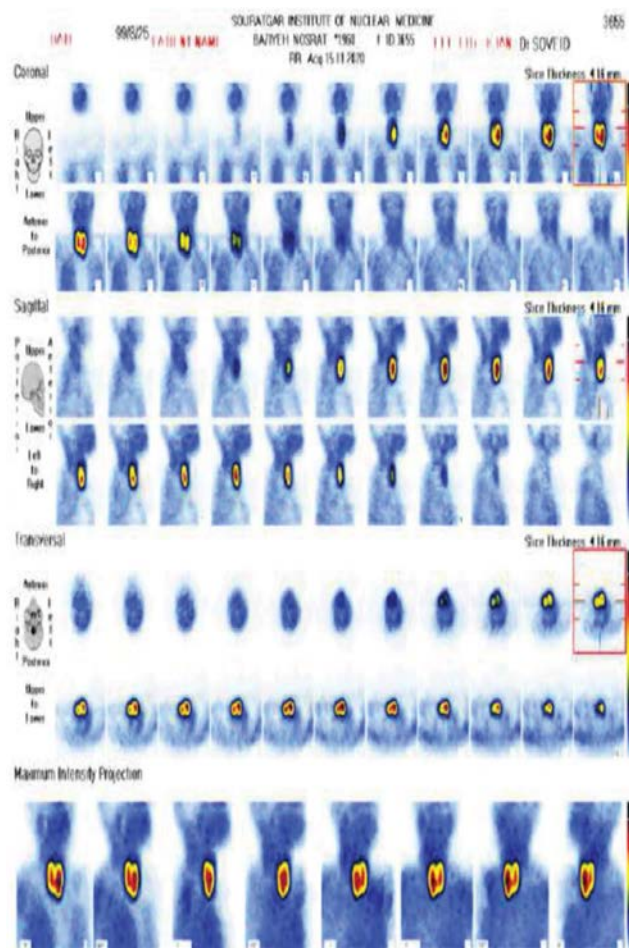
53-year-old woman was consulted for hyperparathyroidism due to severe fatigue and mild dyspnea. Individuals are more often diagnosed today through routine biochemical laboratory testing done for other purposes [1]. Laboratory assays showed hypercalcemia: 10 mg/dL, high serum level of parathyroid hormone: (80 pmol/L), and normal serum phosphorus level 3 mg/dL. [<sup>99m</sup>Tc]MIBI parathyroid scintigraphy was performed.
